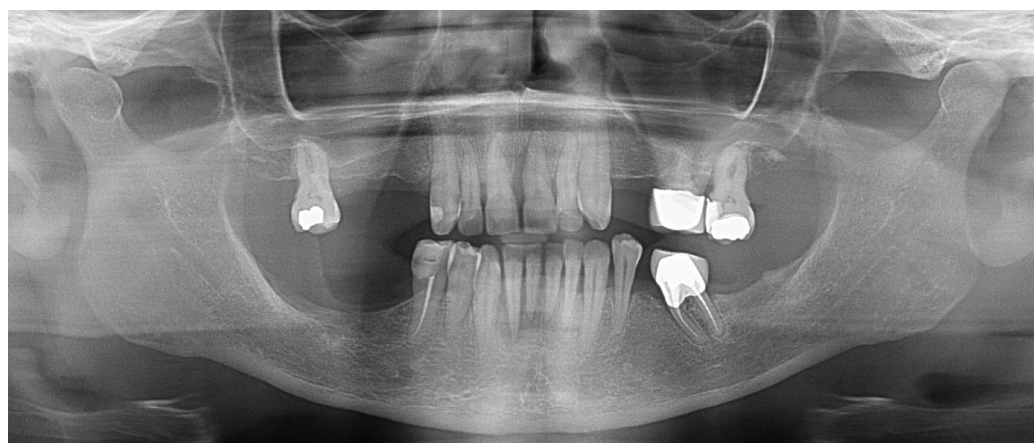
Panoramic radiograph obtained two years prior to referral, showing a partially dentate patient with teeth 21 and 22 still present, with a greater number of remaining teeth compared with the CBCT examination performed at the time of presentation.
